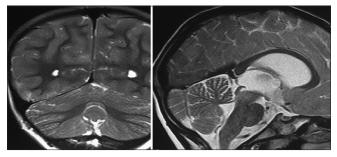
Magnetic resonance imaging findings in acute disseminated encephalomyelitis
